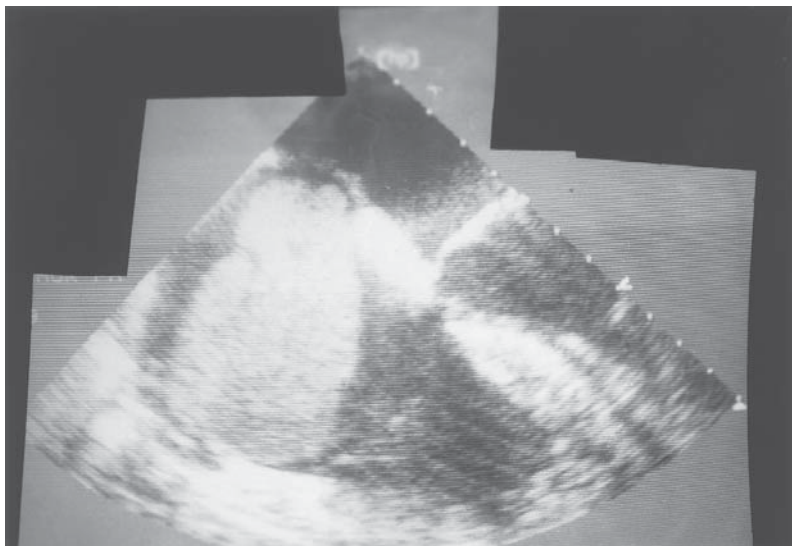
Intraoperative ultrasound showing intracaval tumor.
